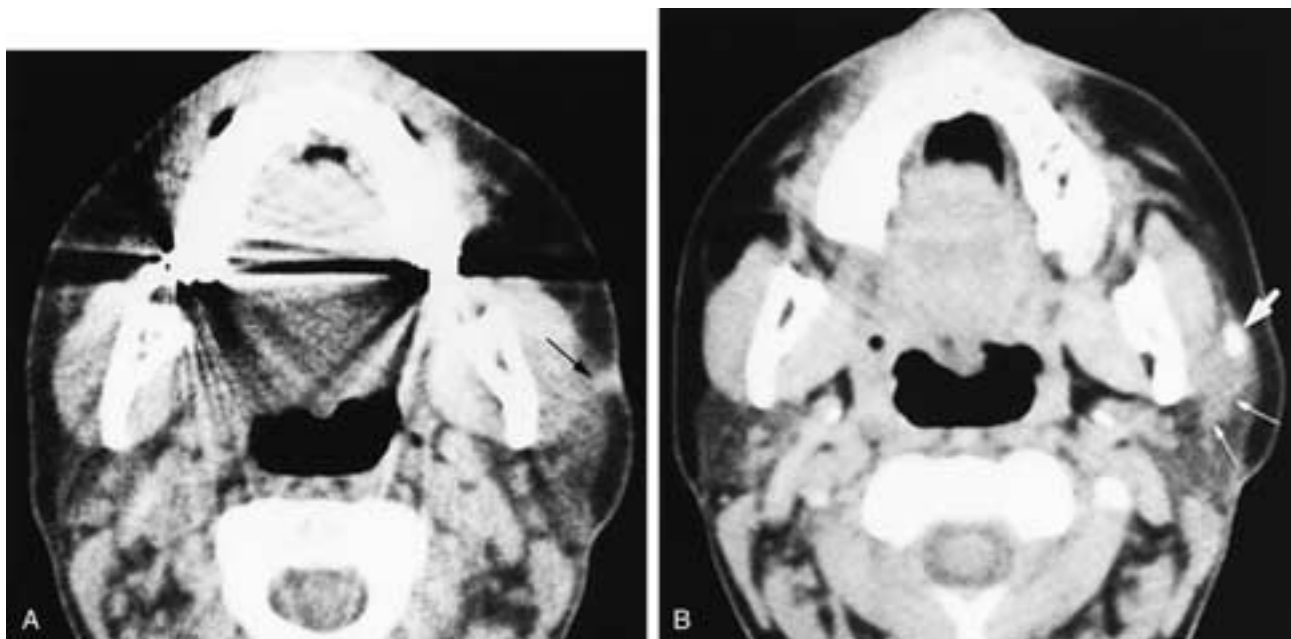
Axial CT scans (A, B) show a small sinus tract (*black arrow*) opening to the skin of the cheek. Clear fluid was draining from this site. In B, a more caudal scan, a small calculus (*short arrow*) is seen that caused obstruction of the saliva and that was not seen on routine plain films. There is increased attenuation in the obstructed parotid ducts just behind the calculus (*thin arrows*). This patient had sialodochitis, sialadenitis, sialolithiasis, and a sinus tract.
